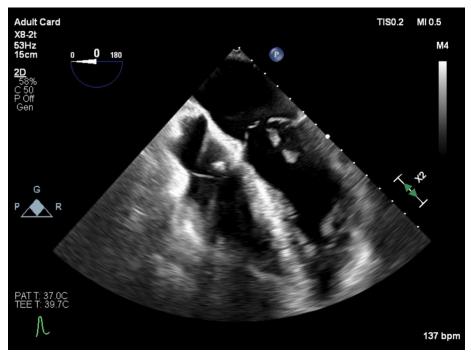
Echocardiogram showing bilateral papillary muscle rupture.
